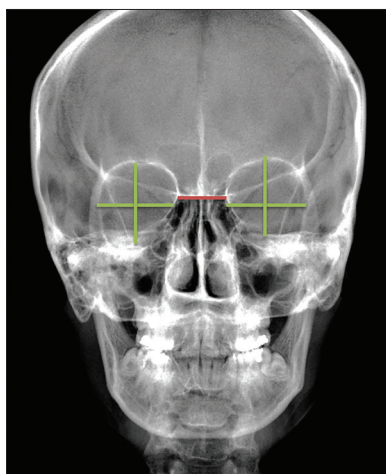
The linear measurements height and width (yellow vertical and horizontal lines) along with interorbital distance (red horizontal lines) on digital posteroanterior radiographic view
